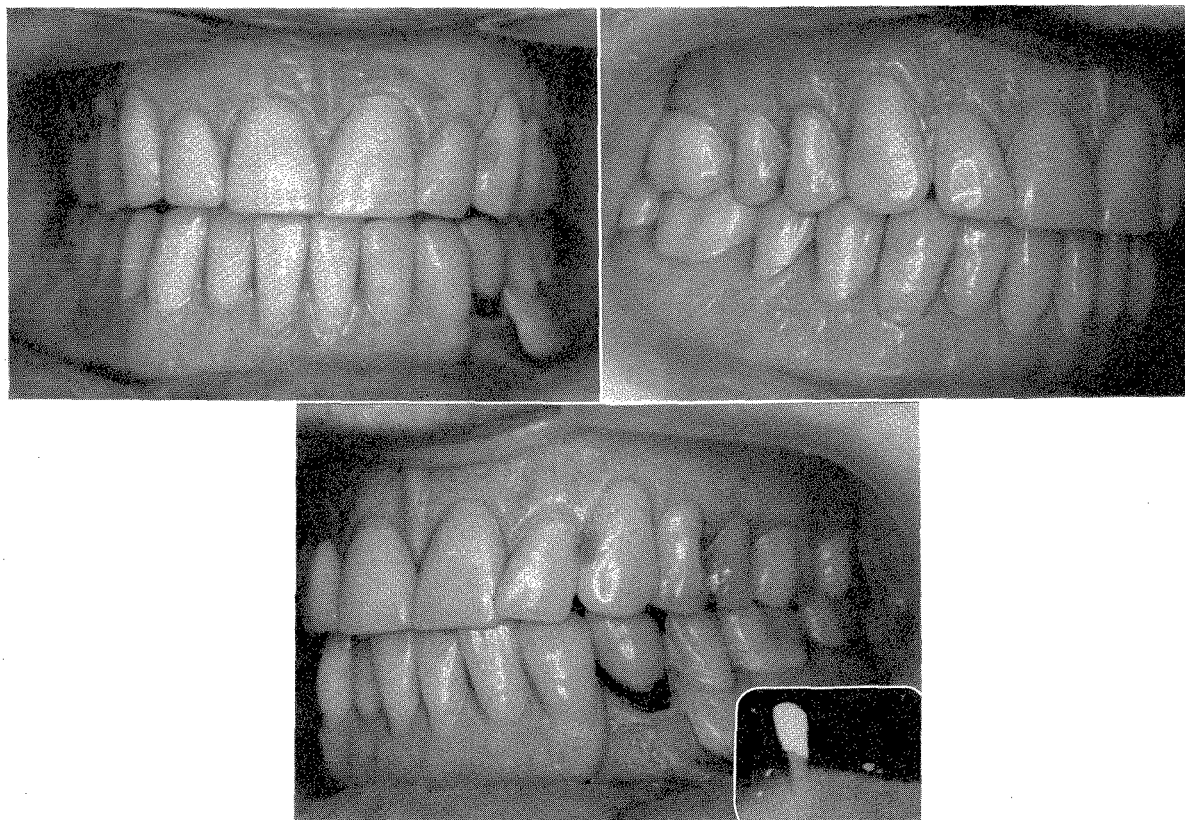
Front, right, and left views of the prosthesis in the mouth. The patient was 66 years old at this time. The radiograph of the left bicuspid taken in 1962 is shown in the inset of the left lateral view.
